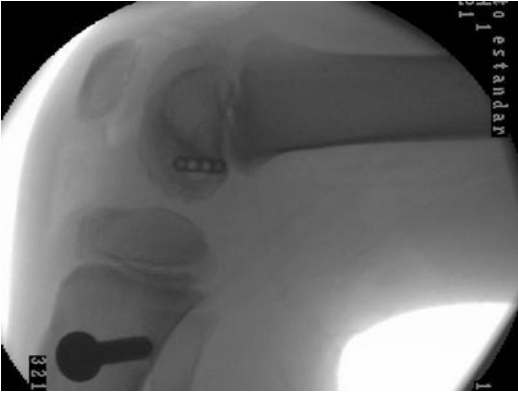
Lateral fluoroscopic radiograph of a prepubescent child showing a femoral all-epiphyseal tunnel and graft fixation with Endobutton. The tunnel is parallel and distant of only a few millimeters to the growth plate. This technique requires a high precision and bears the risk of creating a larger growth plate injury as compared with a transphyseal technique (Courtesy of JC Monllau, MD, Barcelona, Spain)
